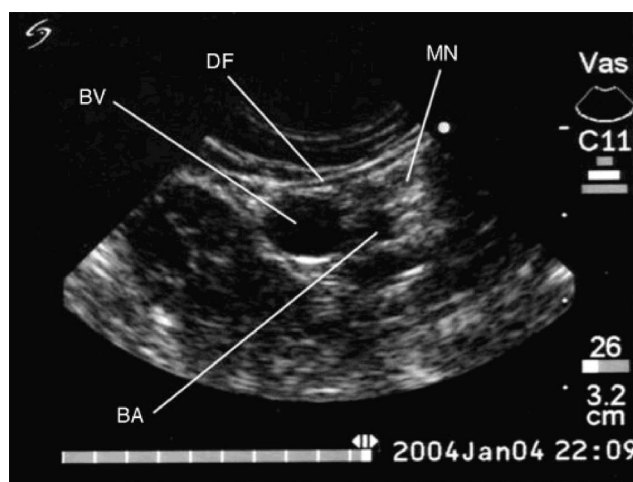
Ultrasonogram shows the basilic vein (BV), brachial artery (BA), median nerve (MN), and deep fascia (DF) in the mid-arm. (From Reference 3, with permission.)
